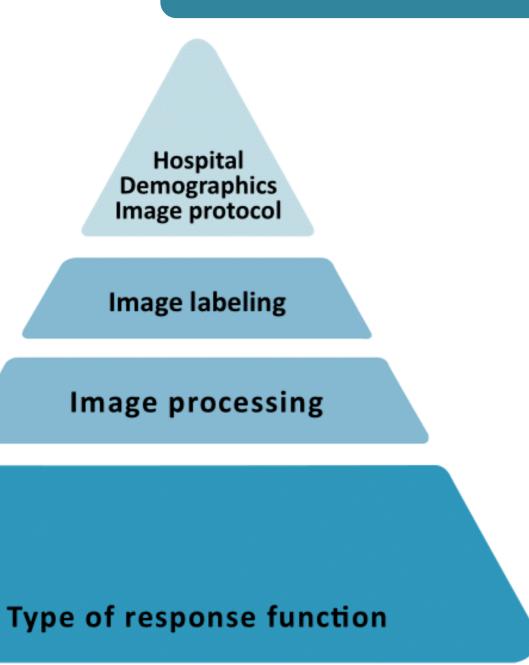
Factors that impact generalization in X-rays.
